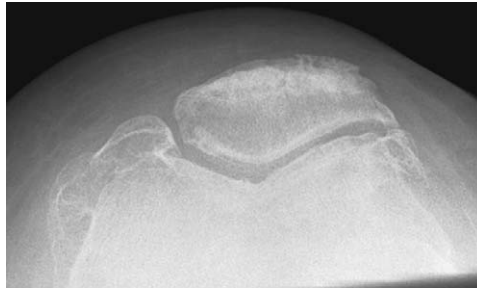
Patellofemoral osteoarthritis. Radiograph demonstrates osteophytes at the PF articulation.
